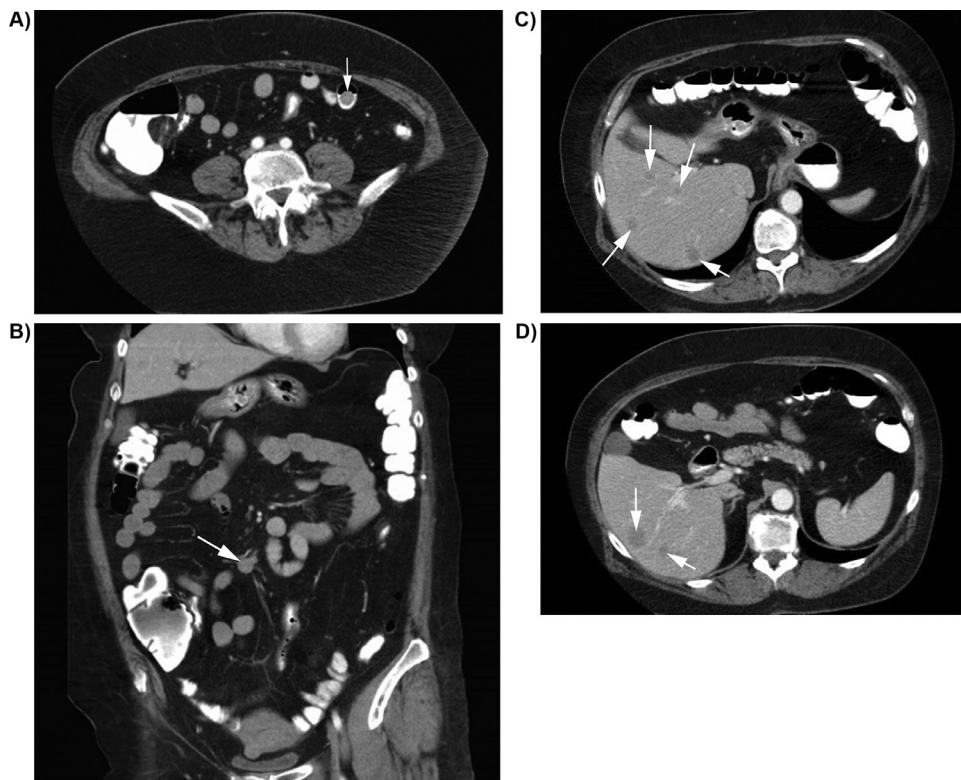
A) CT scan showing a primary SBNET (white arrow). The patient is a 67 year old woman who presented with abdominal pain, diarrhea, and flushing. She was determined to have an ileal NET with numerous hepatic metastases. She underwent laparotomy, small bowel resection, and enucleation and ablation of multiple (>30) liver lesions. B) Coronal CT scan with nodal metastases (white arrow) from the same patient. Nodal metastases can cause a local desmoplastic response, causing calcifications and fibrosis that result in a characteristic stellate pattern with spiculations on CT (not present here). C) CT scan from this patient demonstrating multiple hypodense liver metastases on the venous phase (C, arrows), which on arterial phase D) tend to be hypervascular and appear as enhancing masses.
